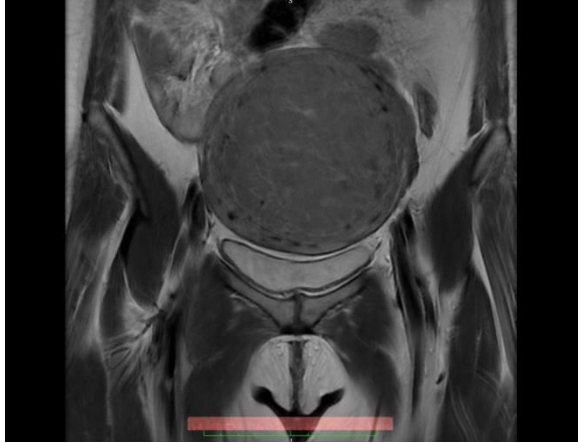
MRI picture of fibroid uterus
